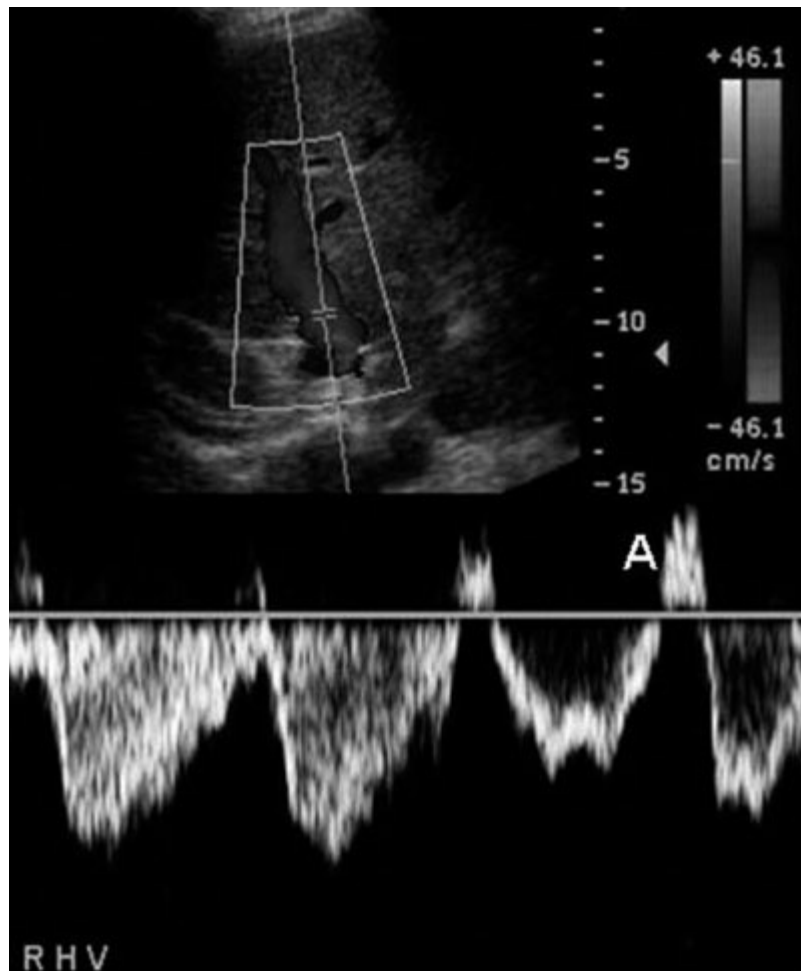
Doppler signal of the normal right hepatic vein. (Color image provided online.)
